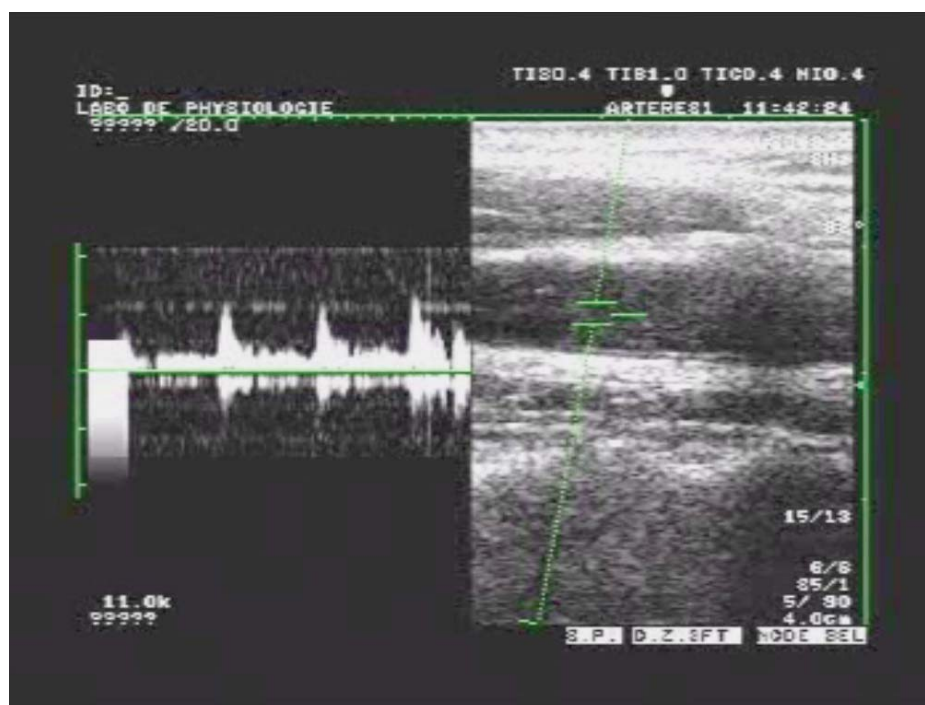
2-D Doppler over the carotid artery demonstrating bubbles passing
